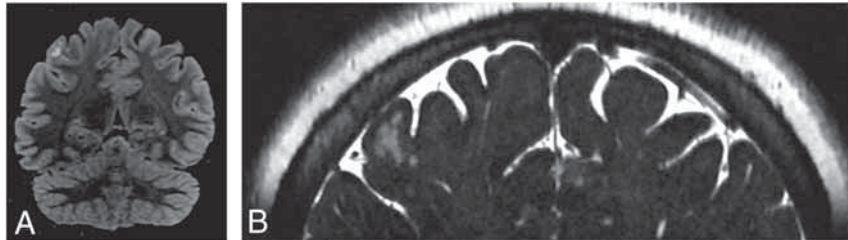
Multinodular and vacuolating neuronal tumor of the cerebrum in a 33-year-old asymptomatic woman. Confluent, small, round lesions in a subcortical location with hypersignal in a T2-weighted FLAIR image (A). They clearly show different signal from the adjacent CSF in a T2-weighted FIESTA image, differentiating them from perivascular spaces (B).
